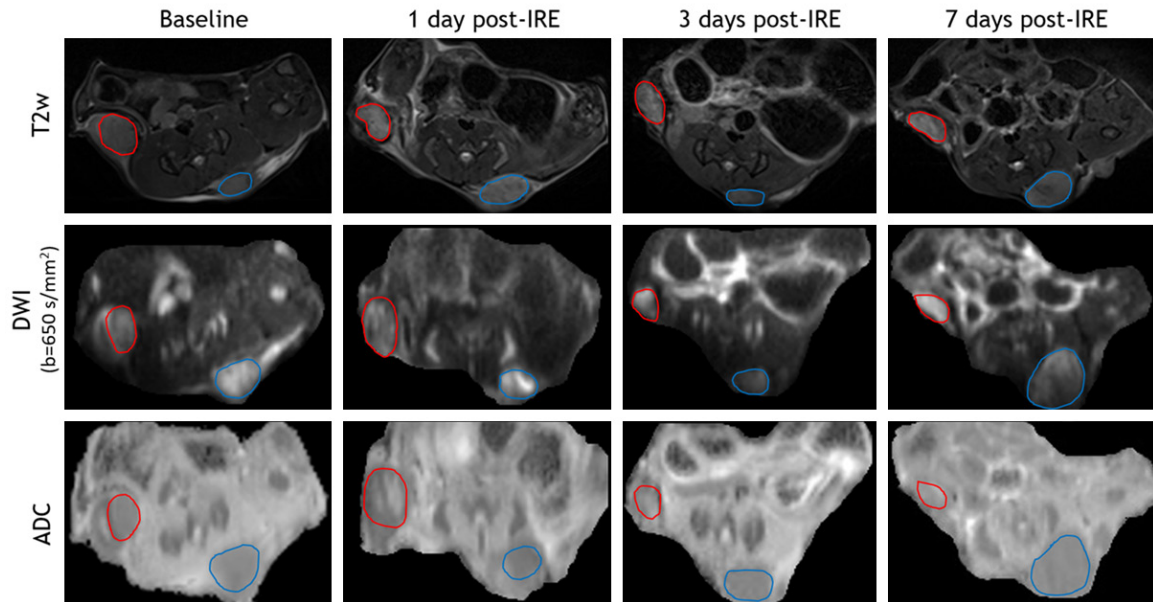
Representative MR images. T2W images, DWI, and ADC maps of baseline, 1 day post-IRE, 3 days post-IRE, and 7 days post-IRE (IRE-treated tumor-red cycle, untreated tumor-blue cycle). These tumor masses were hyperintense (signal intensity is higher than normal muscle signal intensity) within T2W images and DWI images. IRE-treated tumors were typically isointense within ADC maps while untreated tumors were hypointense.
